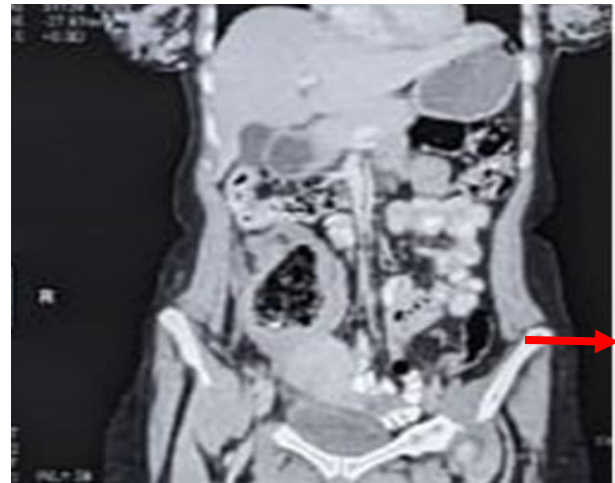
Pre-operative picture of abdominal CT scan showing mass with internal spongiform appearance and calcification
